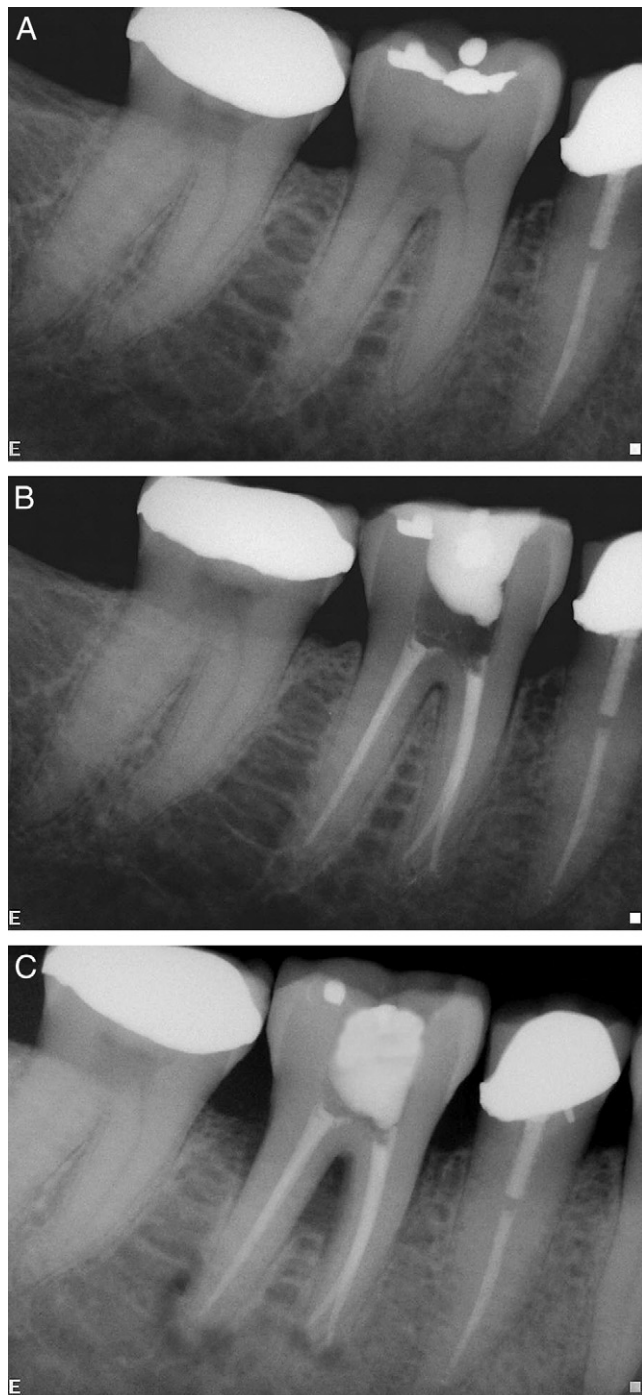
Endodontic treatment without the suspicion of an extensive longitudinal crack as the cause of the tooth necrosis. (A) A mandibular first molar (not from this study) with nonvital pulp before endodontic treatment. Note the minimally deep occlusal restoration. (B) A postendodontic treatment radiograph. (C) Re-evaluation 3 months later. Note the extensive furcation, crestal, and periapical bone resorption. After extraction, a vertical root fracture was observed.
